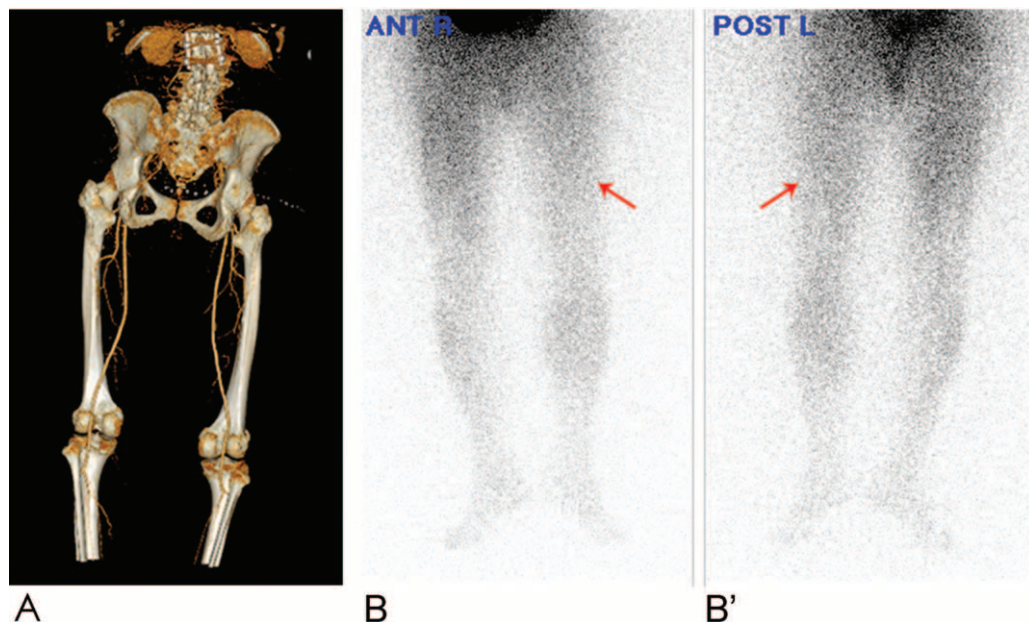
A 75-year-old female with left lower-limb pain. (A) Computed tomography angiographic examination manifests no definite deep vein thrombosis (DVT) or peripheral arterial occlusive disease (PAOD). (B and B') Compared with the right limb, decreased perfusion at the left limb (red arrowheads) was observed by lower-limb thallium-201 scintigraphy (perfusion difference: 0.87).
